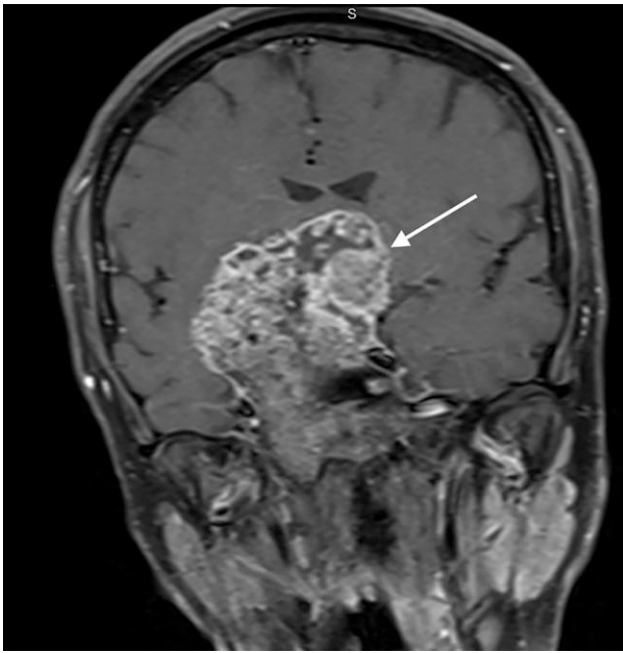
Magnetic resonance imaging of the brain (T1-weighted coronal view) demonstrating a large skull base mass, concerning for an enchondroma, with invagination into the brainstem, including into the pons and to the level of the middle cerebellar peduncle. The size of the mass is approximately 4.7 cm × 5.5 cm. There is mass effect upon the inferior right basal ganglia and inferior frontal lobes.
